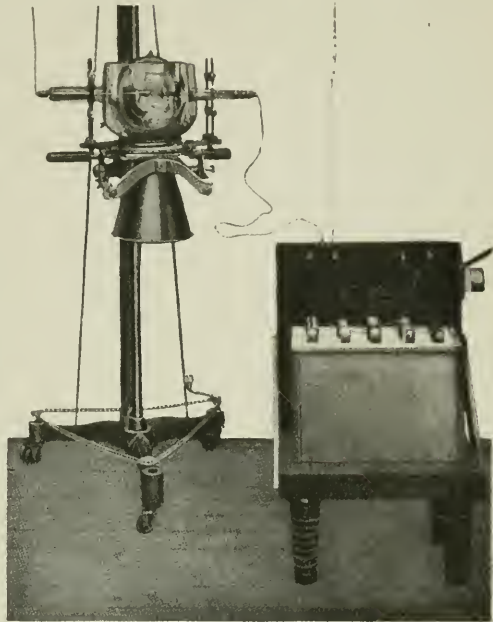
Complete Coolidge X-ray equipment in position. (B.T.H.)
